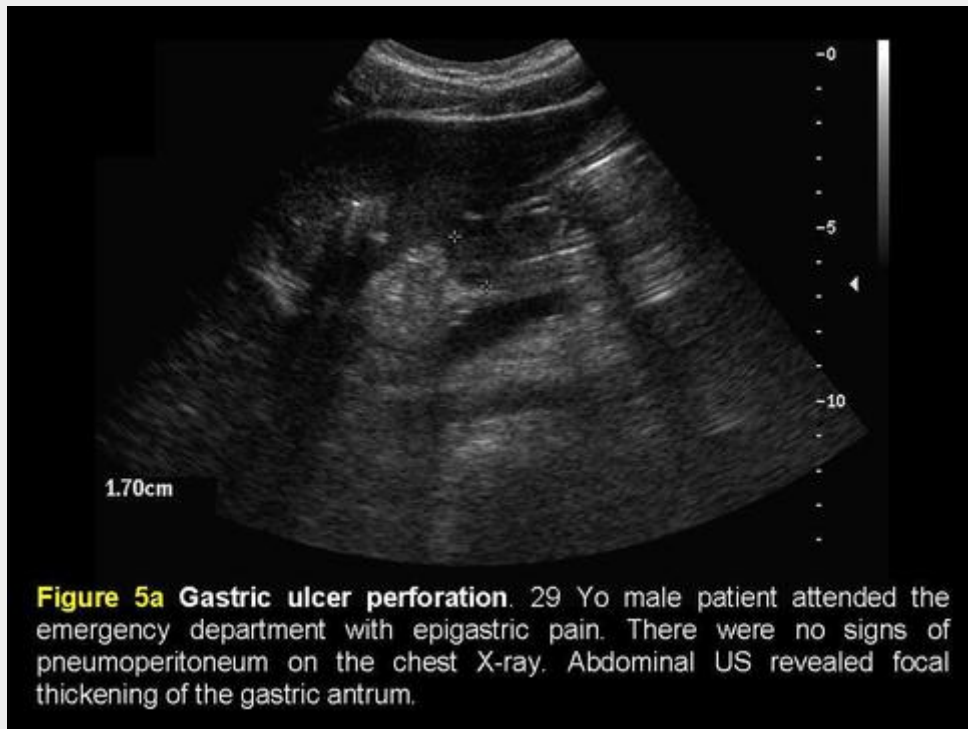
Gastric ulcer perforation. 29 Yo male patient attended the emergency department with epigastric pain. There were no signs of pneumoperitoneum on the chest X-ray. Abdominal US revealed focal thickening of the gastric antrum.
